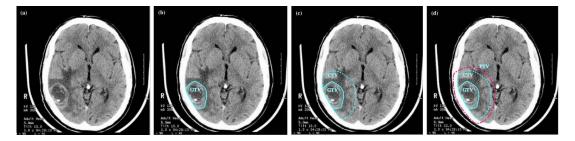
CT image with contrast-enhancing of a patient with WHO grade IV glioma and its three different tumour target volumes; GTV, CTV, and PTV [24].
